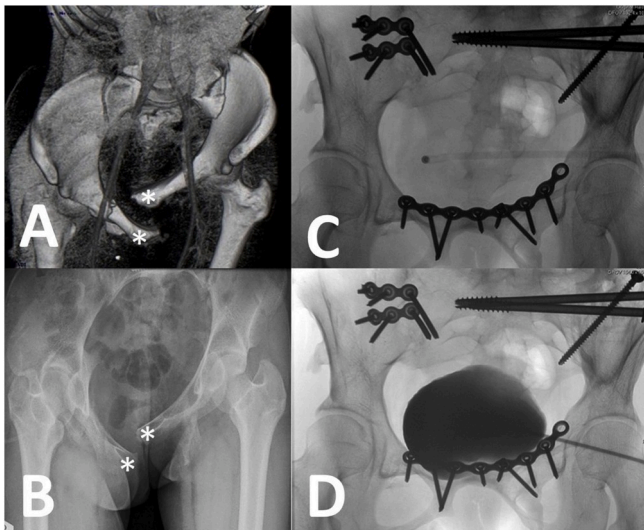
A) 2008: 3-D-CT-reconstruction of pelvis and big vessels on admission to emergency room. Asterisks indicate extreme dislocation of symphysis, thus pelvic floor rupture and urethral avulsion from bladder neck. B) 2008: Widening of symphysis indicated by asterisks after sacral stabilization. C) 2018: Overview of pelvis at clinical presentation during consultation to “get rid of suprapubic tube”. D) 2019: X-ray during videourodynamics showing bladder with 500ml capacity. The suprapubic catheter is in-situ and the bladder neck closed without remaining urethral or sphincter structures.
